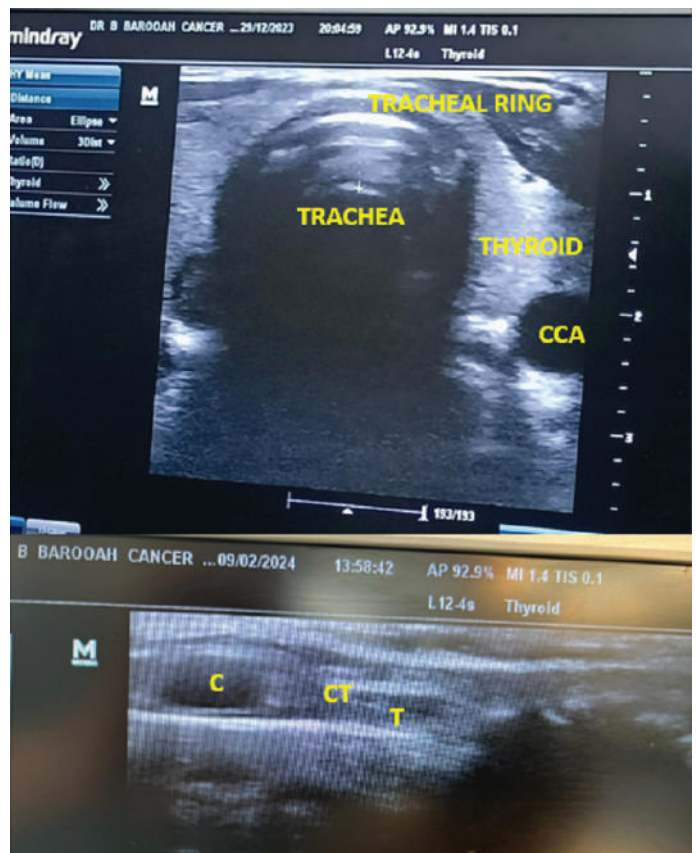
Normal Sonographic Infrahyoid Anatomy.
